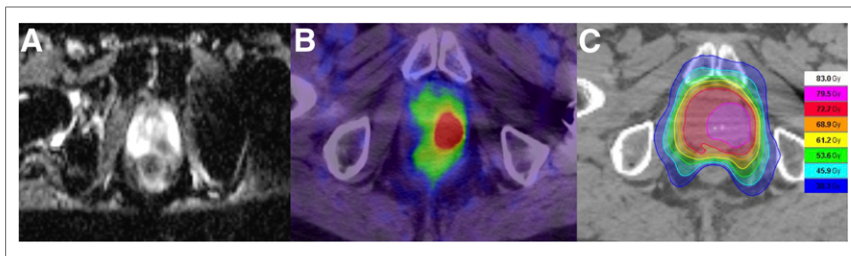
Relevant data for intraprostatic boost during radiotherapy: MRI of prostate with apparent diffusion coefficient sequence (A), PSMA tracer uptake in PSMA PET/CT (B), and radiation plan with irradiation of prostate and simultaneous integrated boost according to pretreatment imaging (C).
